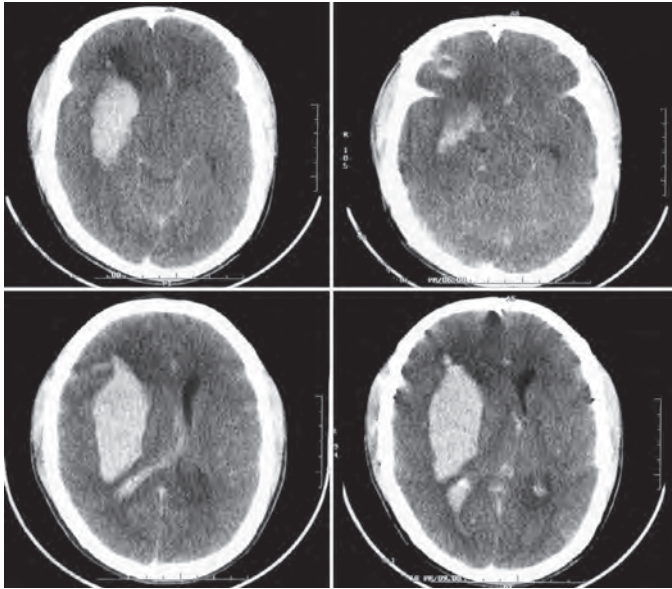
CT showing Rt. frontotemporal ICH (deep) with IVH
